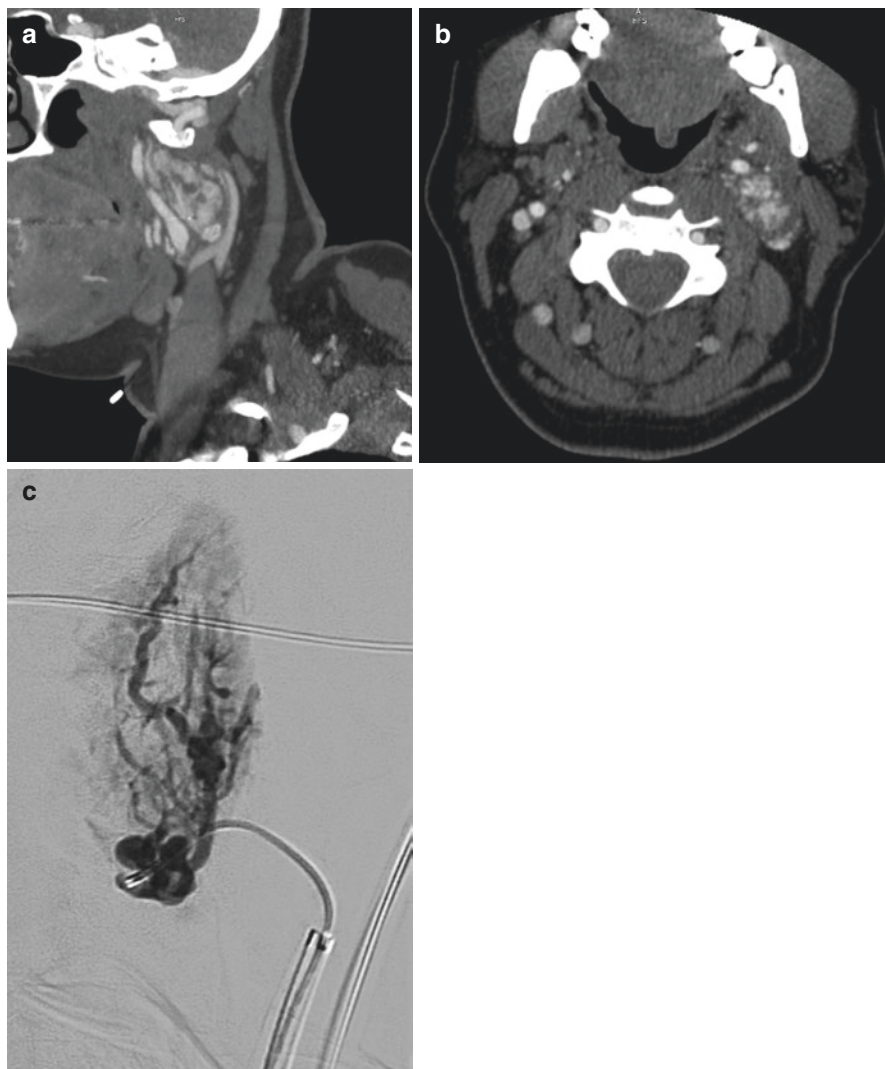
(a) Oblique reconstruction of the CT angiogram revealing the dimensions of the left glomus vagale tumor described in case example 2. (b) CT angiogram axial slice revealing the glomus vagale tumor on the left approximating the internal carotid artery with no evidence of vessel narrowing. (c) Digital subtraction angiography lateral view with selective injection of the tumor prior to selective embolization
